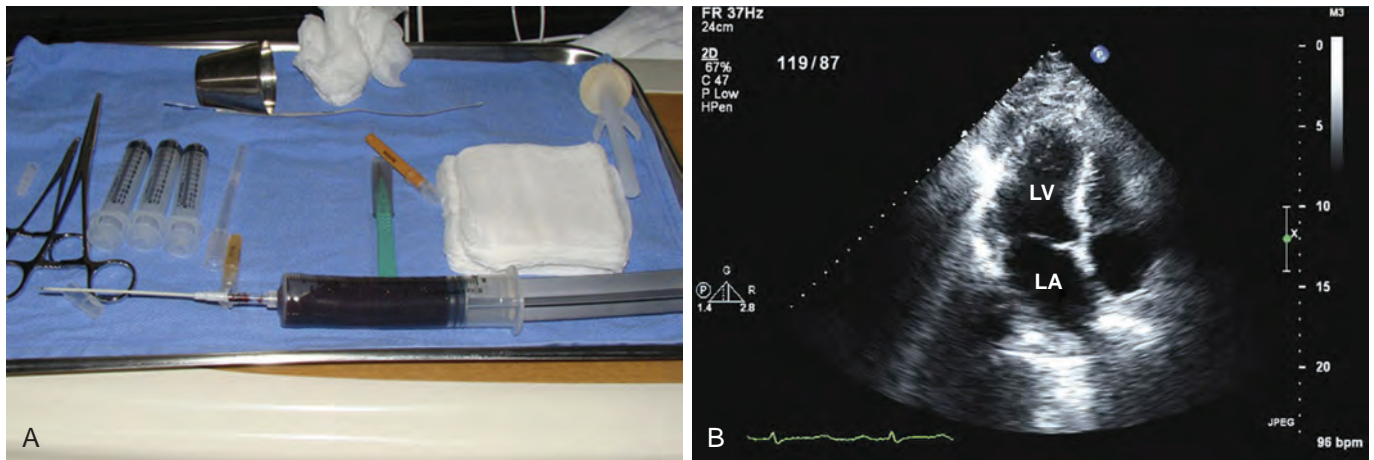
(A) The catheter and syringe that are used for the pericardiocentesis are shown. (B) Trans-thoracic echocardiogram parasternal four-chamber view shows resolution of the pericardial effusion. The right side of the heart is now well filled in diastole. LA, left atrium; LV, left ventricle.
